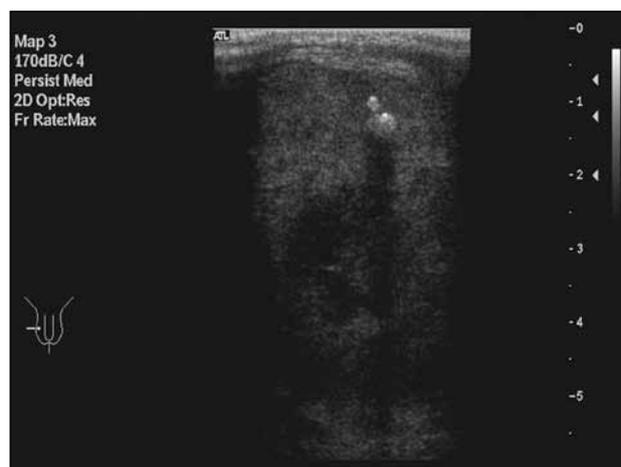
Ultrasonography of the right testicular lesion showing tiny calcifications.
